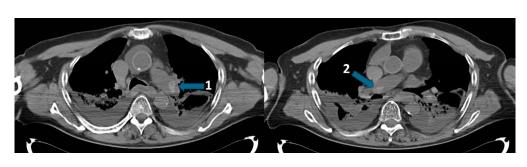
Example where pulmonary embolisms were diagnosed at antemortem ultrasound and postmortem CT but were not confirmed during autopsy.
